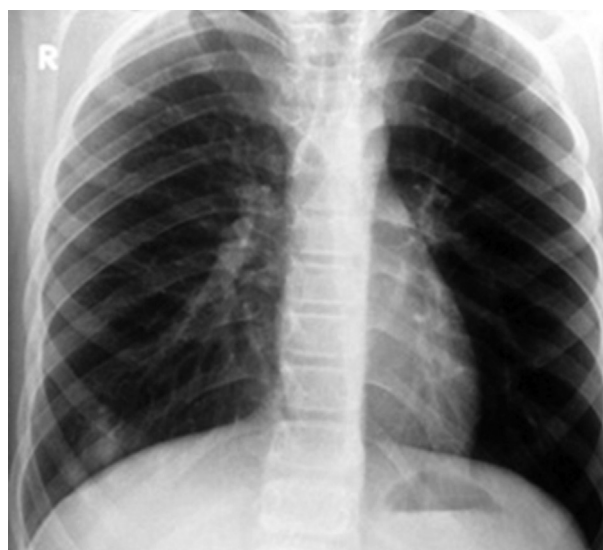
Patient's radiograph at first presentation, posteroanterior projection.
